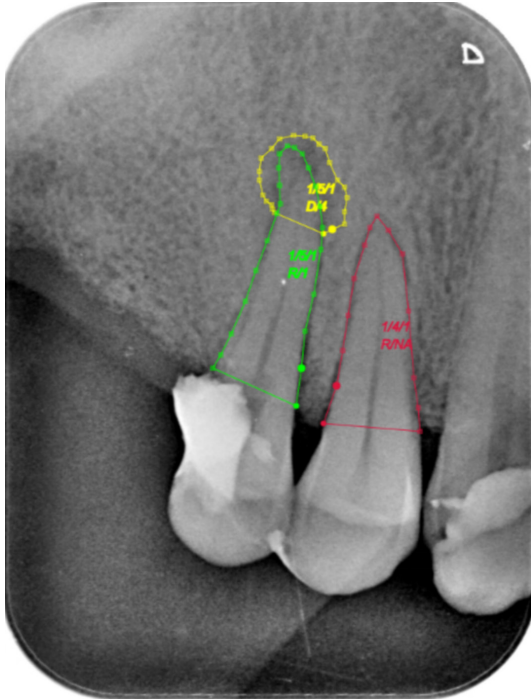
Example of annotation on periapical radiographs. (THE green curve outlines the root of the right maxillary second premolar, and the yellow curve delineates the corresponding apical lesion; The red outlines the root of the right maxillary first premolar. No apical lesion boundary was annotated for the right maxillary first premolar because the observer did not identify any periapical radiolucency around its root).
